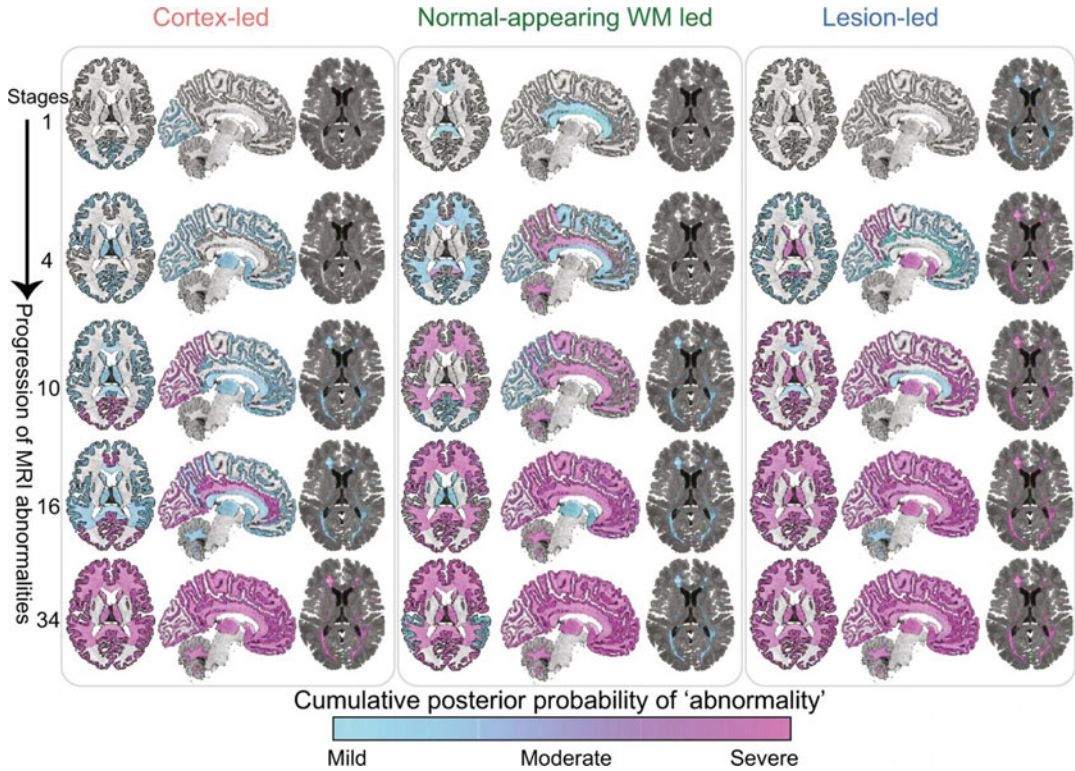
Evolution of MRI abnormalities in each of the three MRI-based subtypes revealed by the SuStain analysis by Eshaghi et al. For each subtype, the left two columns depict the probability of regional brain atrophy, and the right column depicts the probability of lesion occurrence in the various stages of MRI abnormality progression. (Figure adapted from Eshaghi et al. [81], CC BY 4.0)
